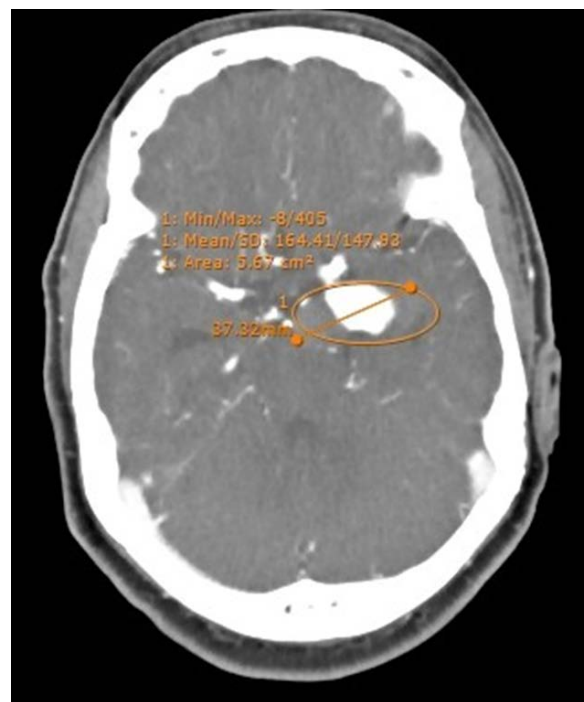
CTA showing giant Pcom aneurysm partially thrombosed.
